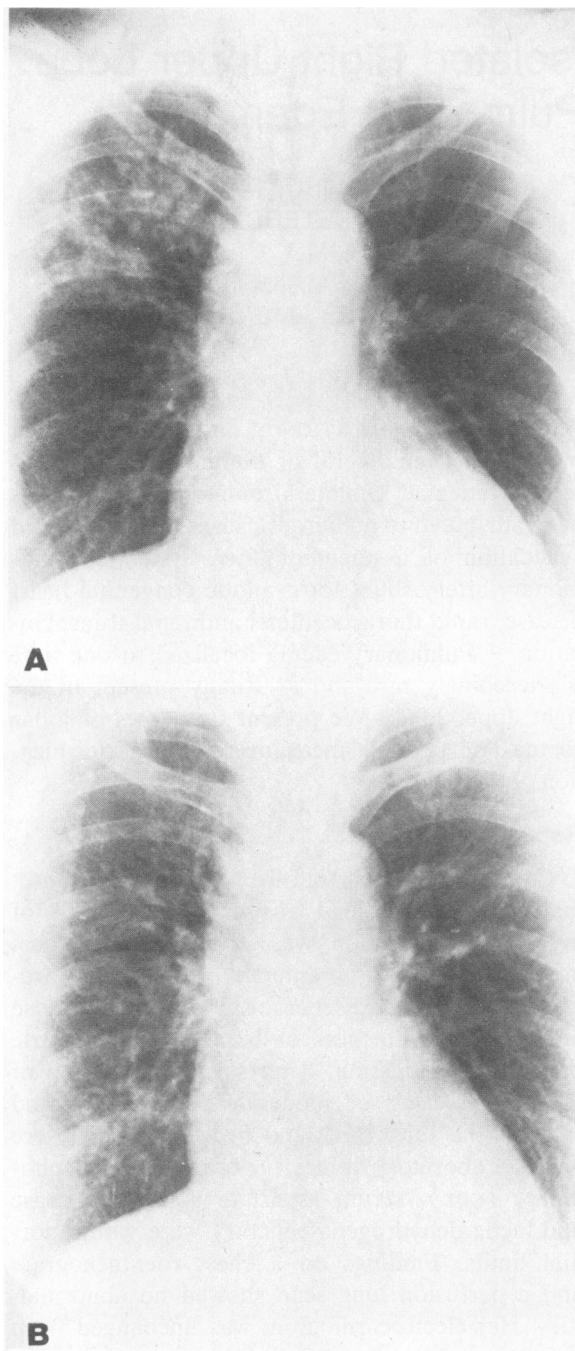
(Case 2) A, Frontal roentgenogram of the chest at the time the patient was transferred shows patchy consolidation in most of the right upper lobe. The remainder of the lung fields is clear and the pulmonary vessels are of normal caliber. Cardiomegaly is visible. B, A roentgenogram done three days later shows the right upper lobe consolidation has completely resolved. The pulmonary vessels and cardiac size are unchanged.
